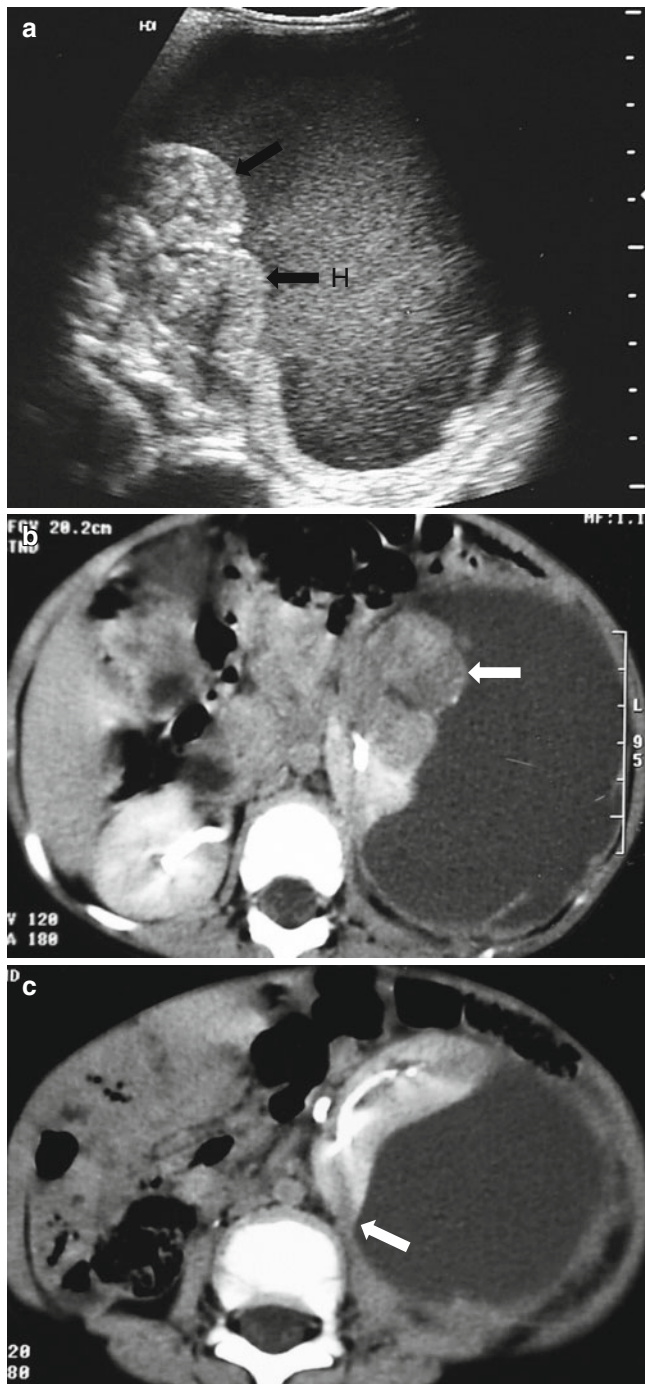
Rhabdoid tumor of the kidney in a 6-month-old boy. (a) Longitudinal US of the left kidney shows a lobulated, heterogeneous hyperechoic mass (*black arrows*) with a large amount of subcapsular hematoma (*H*). (b) Contrast-enhanced CT scans show a poorly enhancing mass (*white arrow*) arising from the left kidney. Note also the large subcapsular hematoma, which is known to be a characteristic finding in rhabdoid tumor. (c) On the CT slice made 4 cm lower, the left kidney is displaced anteriorly by the subcapsular hematoma. Note the displaced renal pelvis and stretched renal parenchyma (*white arrow*)
